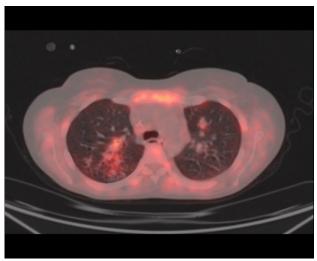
PET-CT with Thorax (axial section). It is suggestive of hypermetabolic lesions in parapharyngeal areas and bilateral lung fields.
